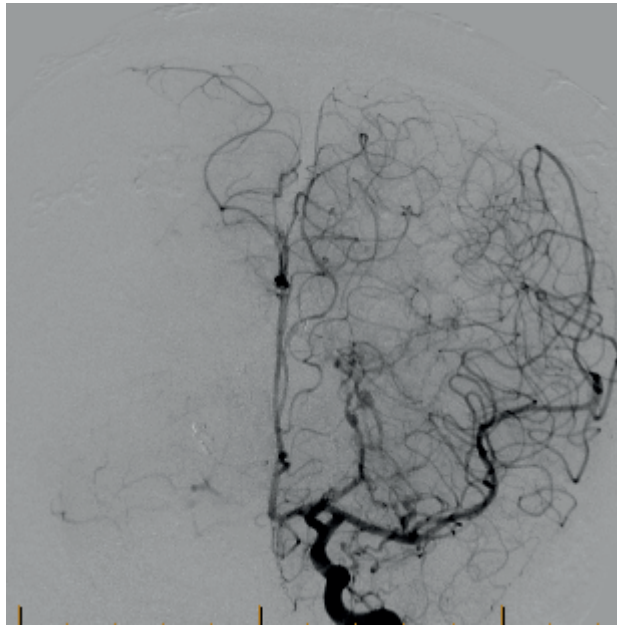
Digital subtraction angiography of the cerebral arteries. Several advantages exist for DSA over less invasive modalities such as CTA and MRA. Techniques including road mapping allow for a previously recorded image of a contrast-filled vessel to be viewed on a monitor, whilst angiographic wires and catheters are passed through this image in real time.
